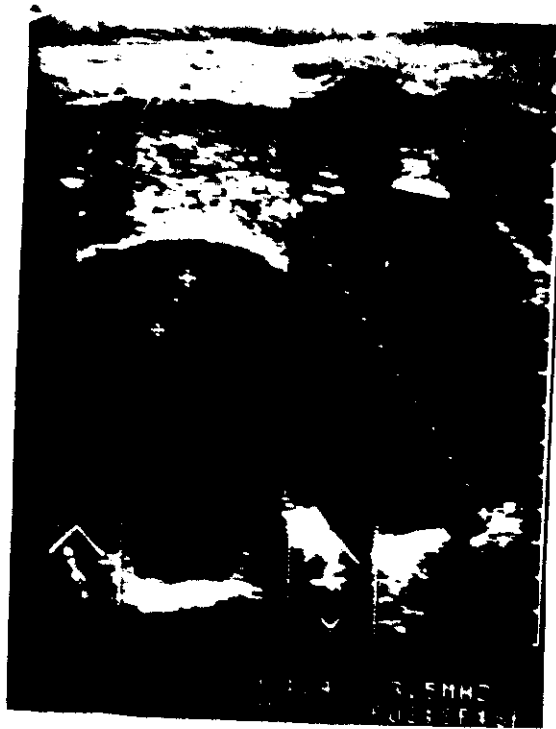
Real time ultra-sonography scan of the liver shows liver simple cyst as echo-free area with a strong back of echo.
